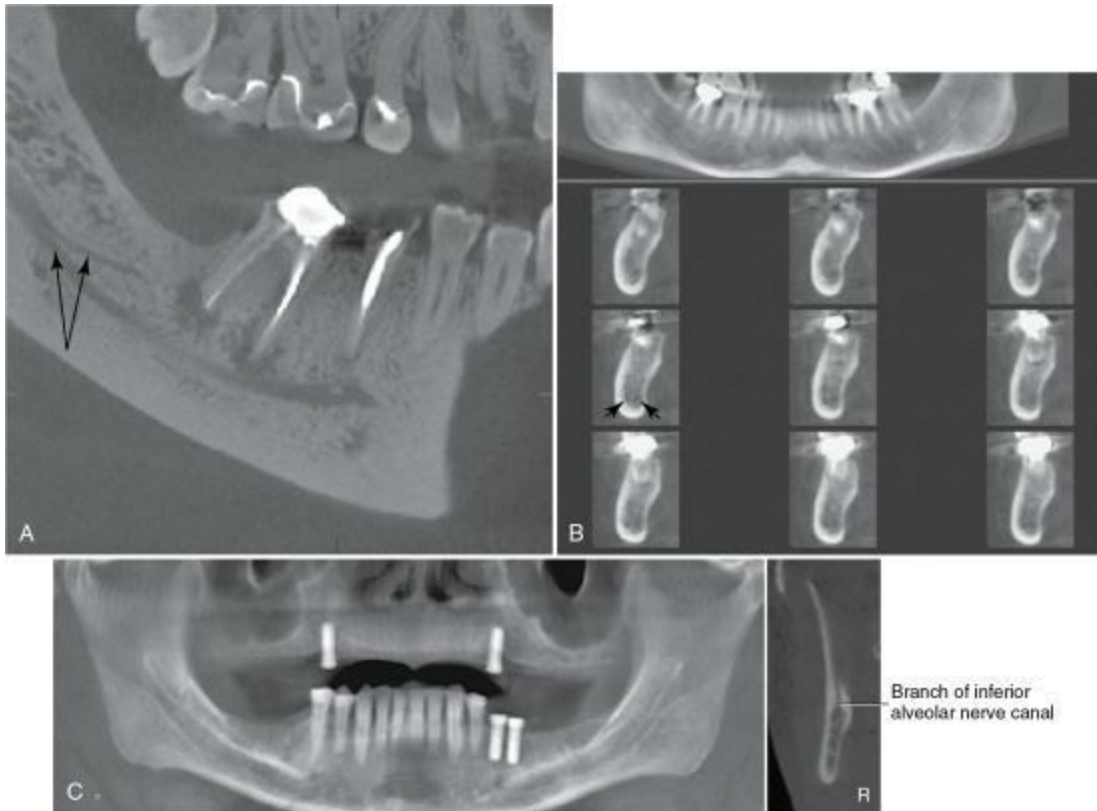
A, Bifid inferior alveolar nerve canal (IANC) visible with cone-beam computed tomography (CBCT). B, Bifid canal visible with CBCT but not shown on Panorex. C, Branch of IANC apparent on CBCT but not shown on Panorex.
